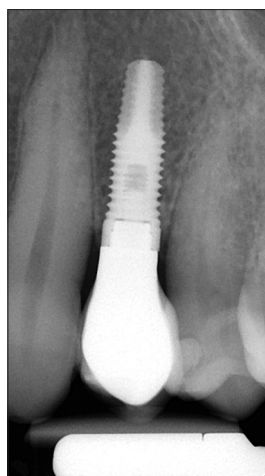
Final restoration pericipical X-ray-2 years follow-up
